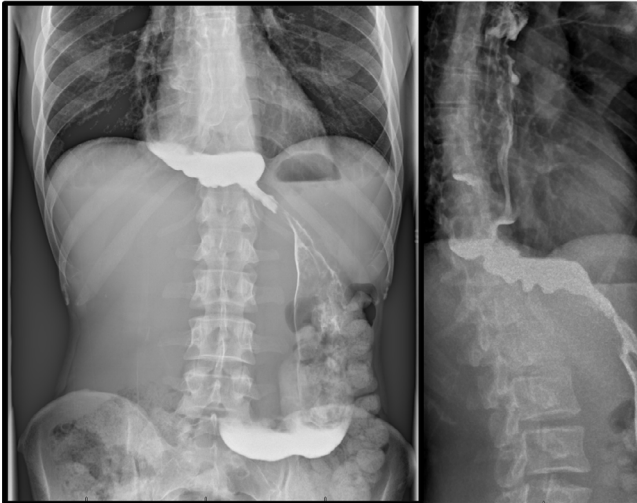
Barium contrast swallow and CT images
